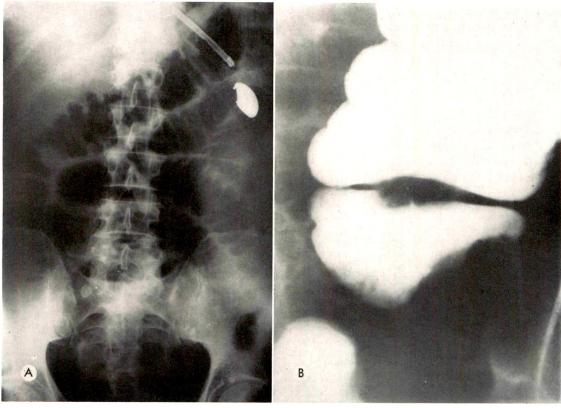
(A) A supine roentgenogram of the abdomen demonstrates a coprolith in the right lower quadrant with loops of dilated small bowel. The clinical picture was that of mechanical small bowel obstruction. (B) A spot roentgenogram of the cecum during a barium enema examination, performed as an emergency procedure, demonstrates an irregular filling defect in the medial aspect of the cecum produced by an appendiceal abscess.
